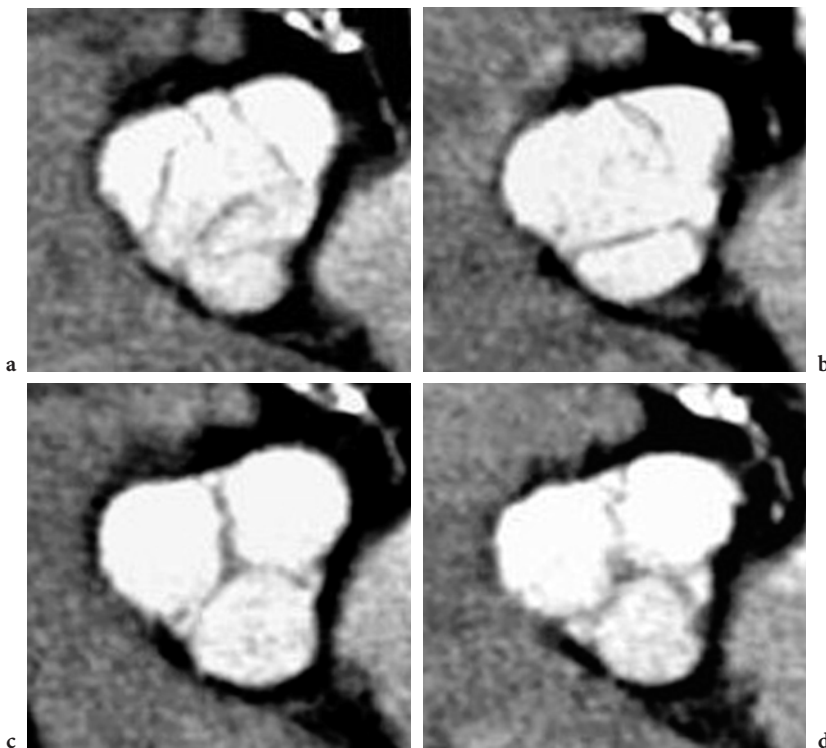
A 54-year-old man with a mean heart rate of 62 bpm, examined with 4-slice CT. Double-oblique multi-planar reformats of the aortic root at the level of the aortic valve as seen from a cranial perspective. Image reconstruction was referenced to four different time points during the cardiac cycle. Motion artifacts during systolic opening of the valve at 0% RR (a) and 20% RR (b) preclude clear demarcation of the valvular cusps. Delineation of the cusps is best at mid-diastolic closure at 60% RR (c) and slightly deteriorates again during late diastole at 80% RR (d)
